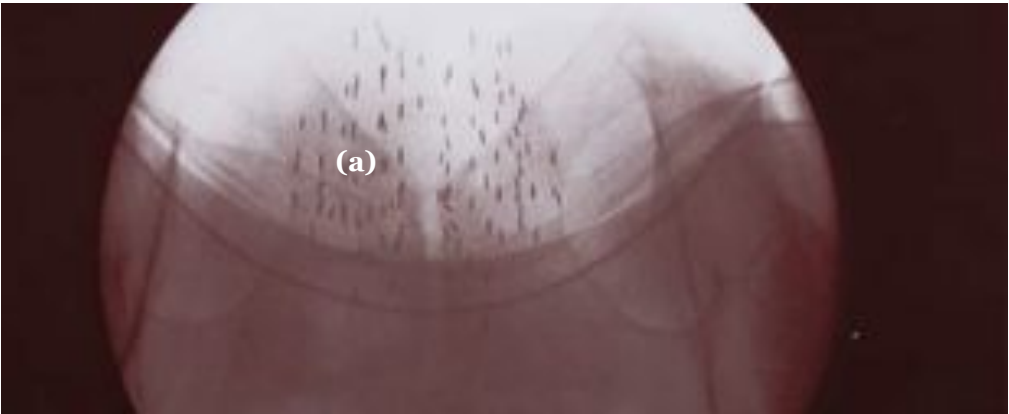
Image Above: This X-ray shows permanent radioactive seeds used for low dose rate brachytherapy in the prostate gland. (a): Multiple strands of seeds evenly spaced throughout the prostate gland.
